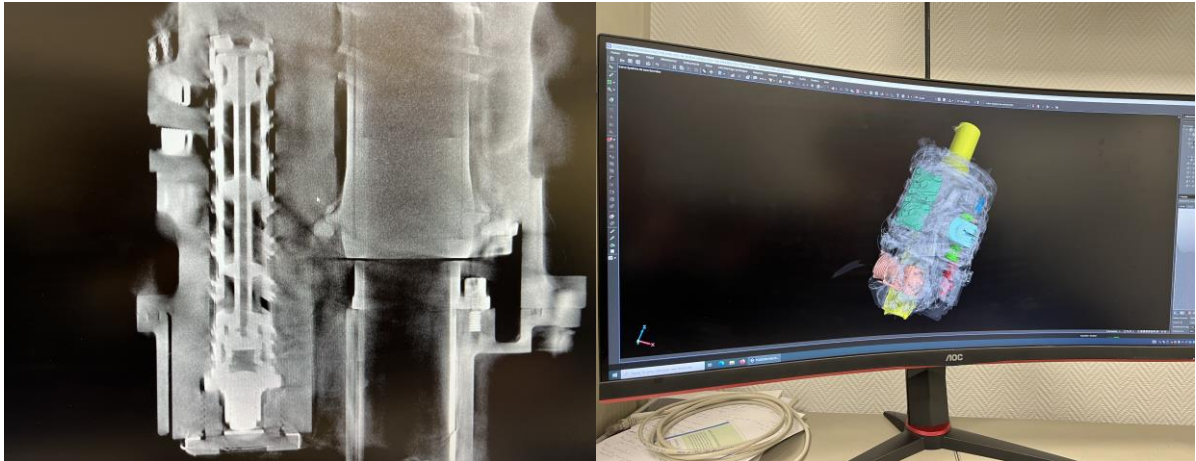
PVM as seen on X-ray during examination
